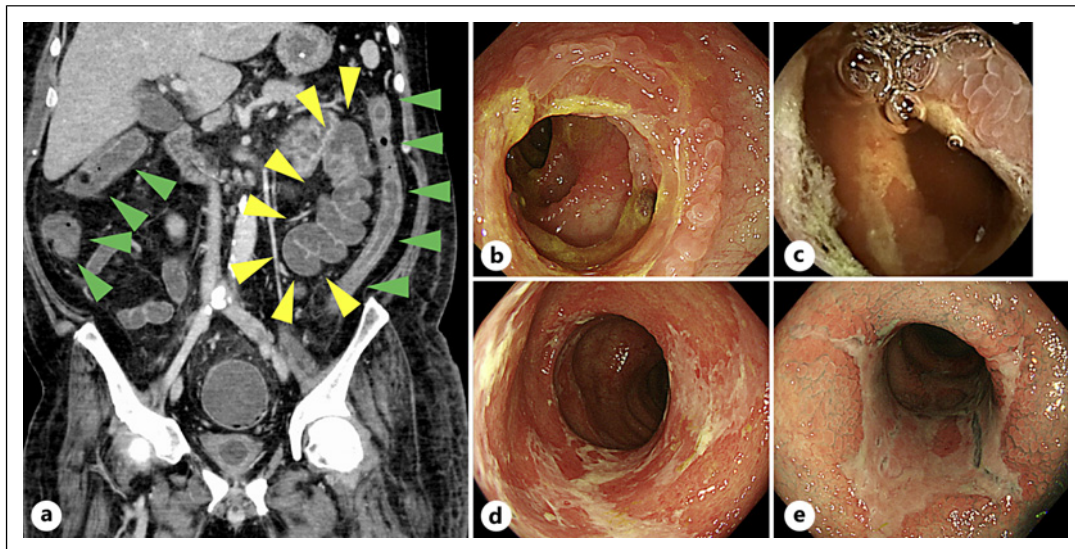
Computed tomography and endoscopic images. a Computed tomography. b Duodenal mucosa by esophagogastroduodenoscopy. c Small bowel mucosa by capsule endoscopy. d Transverse colon. e Sigmoid colon by colonoscopy. Contrast-enhanced computed tomography revealed severe edema of the colon (green arrows) and intestinal fluid accumulation of the entire small bowel (yellow arrows) (a). Esophagogastroduodenoscopy revealed villous swelling and ring erosions in the duodenal mucosa (b), while no abnormalities were observed in the esophagus or stomach. Capsule endoscopy revealed villous swelling, erosions, and shallow ulceration throughout the small bowel mucosa (c). Colonoscopy revealed a shallow ulceration in the entire colonic mucosa (d, e).
